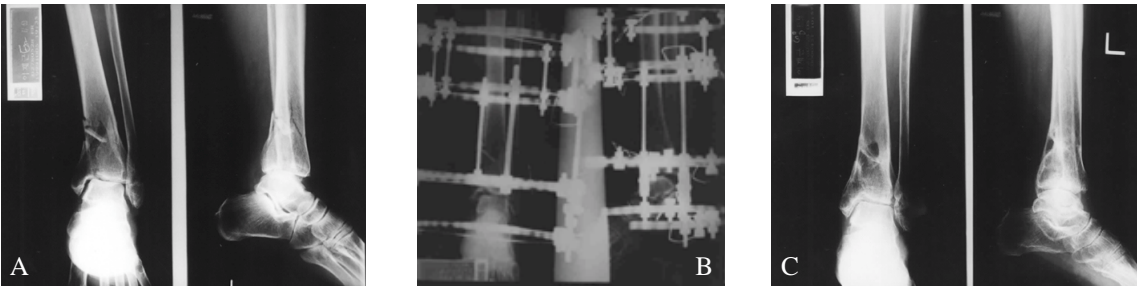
A 65-year-old male has broken his left ankle after a fall down (A). He underwent an operation for closed reduction and external fixation with Ilizarov device for the intra-articular fracture (B). The postoperative radiography in 6 months after removal of the external fixator showed complete union of the fracture (C).
